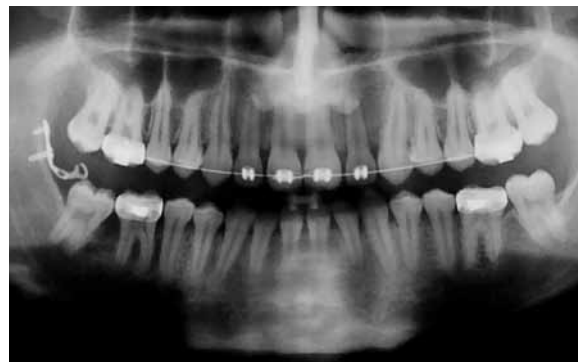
Panoramic radiograph shows tooth 47 in correct position after 3-months treatment.
